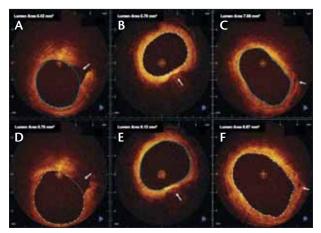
Examples of differences in lumen measurements between OCT with and without balloon occlusion. This figure shows corresponding images acquired with occlusion (A–C) and without occlusion (D–F). The white arrows indicate the landmarks used in the study for matching of the pullbacks (side branches in A and C and calcium spot in B). In all examples, the lumen dimensions are smaller in the pullback acquired with occlusion. Reproduced with permission from Gonzalo N, Serruys PW, Garcia-Garcia HM, et al. Quantitative ex vivo and in vivo comparison of lumen dimensions measured by optical coherence tomography and intravascular ultrasound in human coronary arteries. *Rev Esp Cardiol*. 2009:62:615–624.⁴⁶
